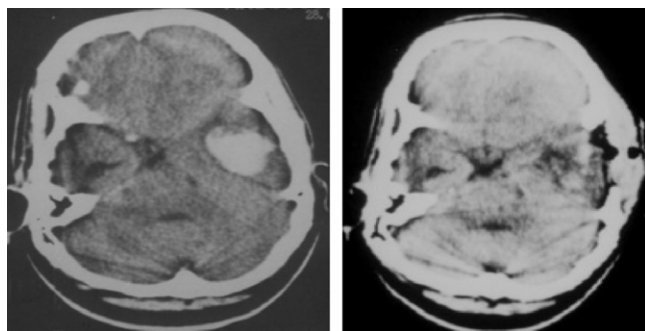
CT scan (axial view) showing left temporal ICH in a 10 years male child suffering from ALL. Post-operative CT scan (axial view) showing complete evacuation of ICH.
